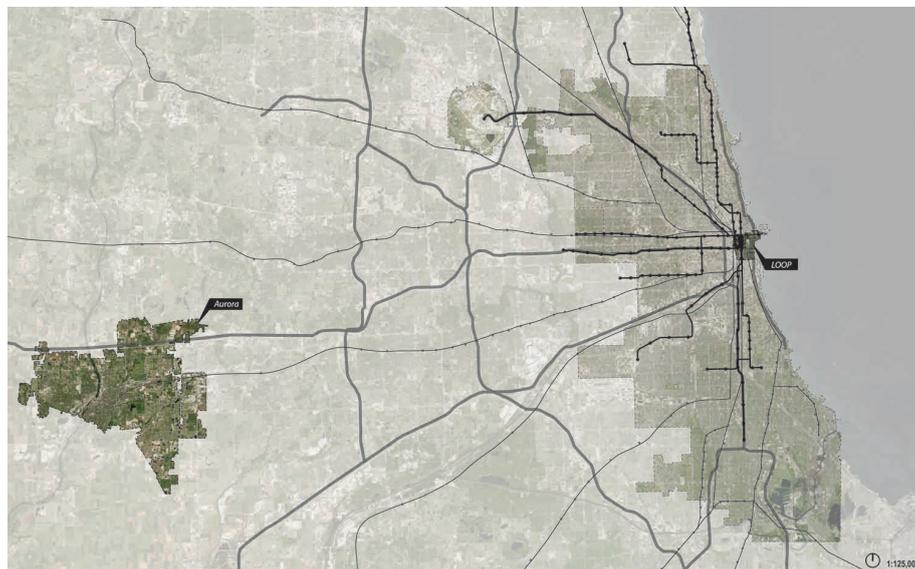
Site locations and transportation systems including Chicago Transit Authority (CTA) train lines, Metra lines, and major highways.
